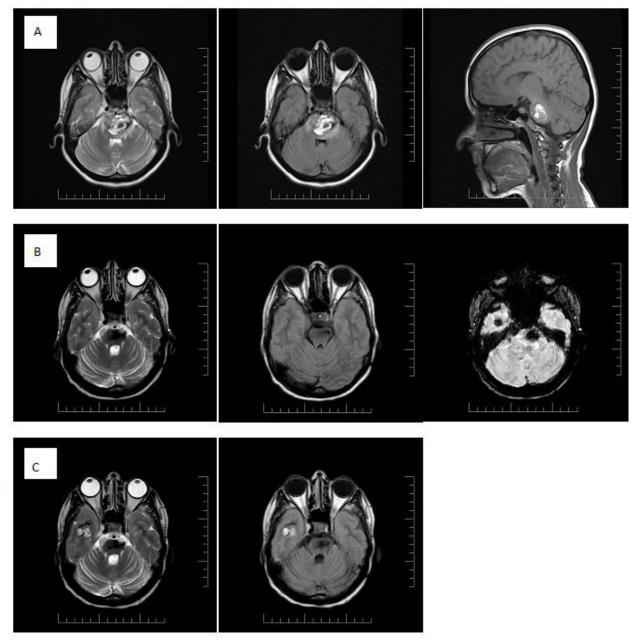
a – MRI of the brain before surgery (signs of cavernoma with hemorrhage of the pons). b - MRI of the brain 6 months after surgery (signs of total removal of the pontine cavernoma, left temporal cavernoma). c- MRI of the brain a year after the operation (signs of total removal of the pontine cavernoma and signs of hemorrhage of the cavernoma of the left (right) temporal lobe.
